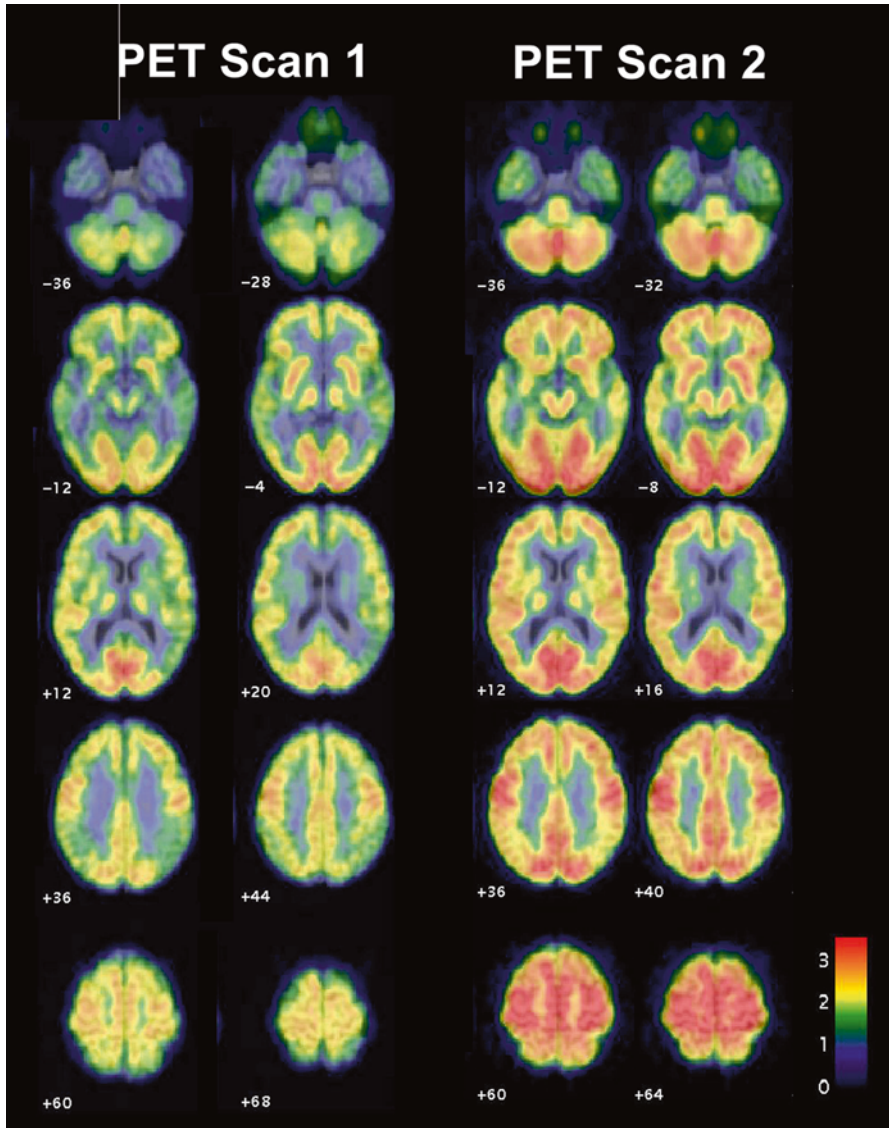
PET scans in patients undergoing NGF gene therapy. Glucose uptake by PET scan in subjects who underwent ex vivo NGF gene therapy, overlaid on standardized MRI templates. Images are average PET data from all four bilaterally treated patients who underwent serial PET scans. Representative axial sections, with 6–8 months between first and second scan, show interval increases in brain metabolism in diverse cortical regions, representing the broad cortical projection pattern of cholinergic systems. Flame scale indicates FDG use per 100 g tissue/min; *red color* indicates more FDG use than *blue* (from [117])
